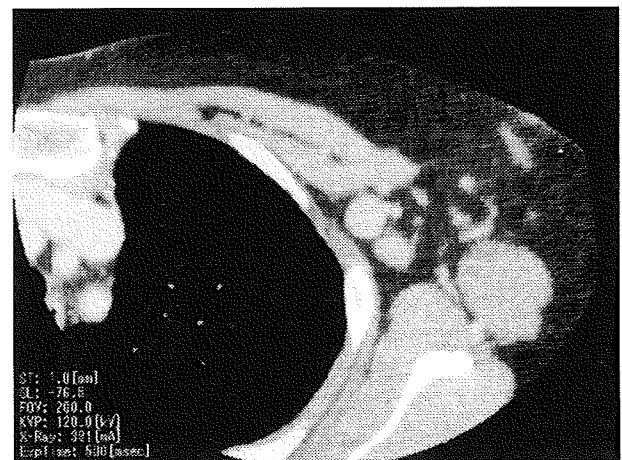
Contrast-enhanced CT showed enlarged axillary lymph nodes on the left
